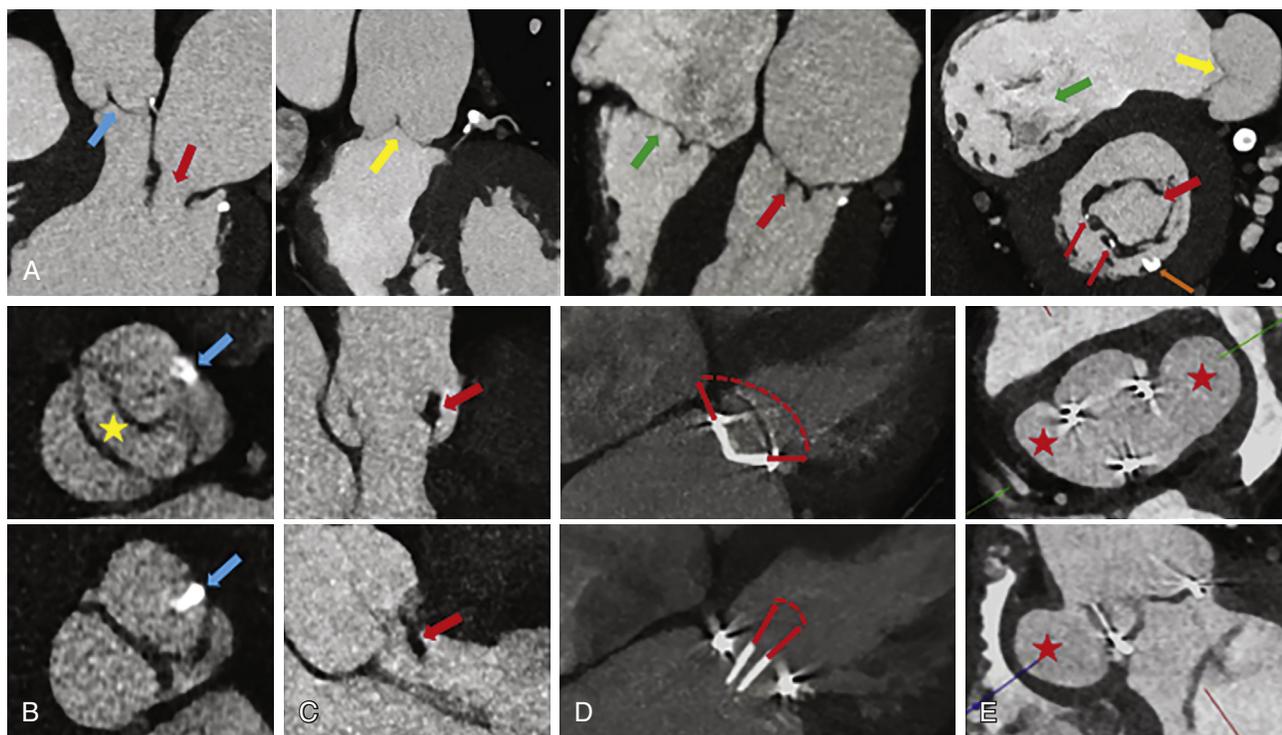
Examples of assessing valvular heart disease on cardiac computed tomography. A, Normal appearances of aortic valve (*blue arrow*), pulmonic valve (*yellow arrows*), and tricuspid valve (*green arrows*) in different phases of the cardiac cycle. Mitral valve (*red arrows*) in different phases of the cardiac cycle; the mitral valve leaflets are mildly thickened with calcifications (*small red arrow*), and there is mild posterior mitral annular calcification (*small orange arrow*). B, Bicuspid aortic valve during systole and diastole. There is fusion of the right and left coronary cusps with calcification of the fusion raphe (*blue arrows*). The bicuspid valve has an elliptical opening (*yellow star*) visualized during systole. C, Mobile aortic valve vegetation (*red arrows*) visualized during systole and diastole (prolapses into the left ventricular outflow tract) in a patient with gram-positive bacteremia and sepsis. D, Normal functioning St. Jude's mechanical bileaflet mitral valve prosthesis during ventricular systole and diastole. The prosthetic leaflets have normal closing and opening angles (*red arrows*). E, Pseudoaneurysms (*red stars*) developed as a complication of bioprosthetic aortic valve infective endocarditis, visualized during systole and diastole. (Courtesy Dr. Vasvi Singh, Brigham and Women's Hospital, Boston.)
